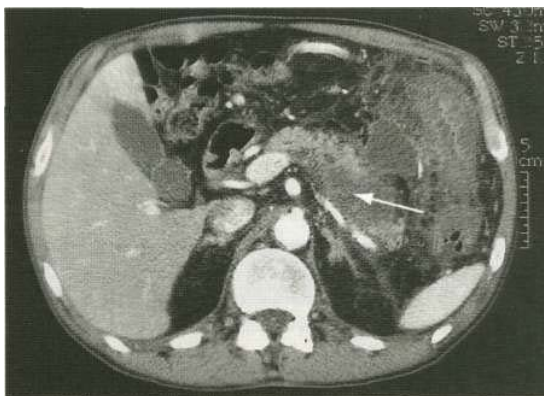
CT scan in patient with acute pancreatitis showing necrosis of the pancreatic parenchyma (arrow) and a fluid collection extending outside the gland with inflammatory thickening of the colon.
